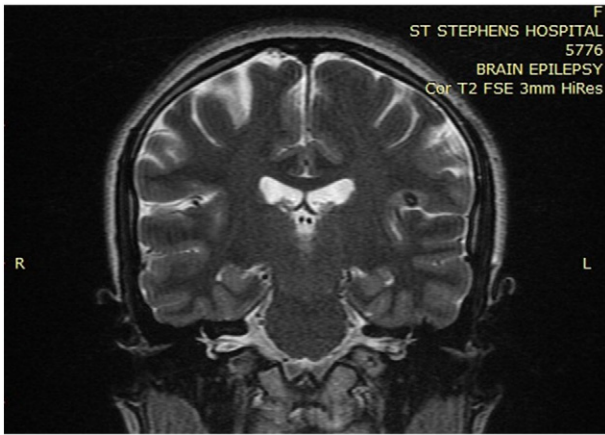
1.5-T MRI coronal T2 showing hypointense round lesion (4.5 mg) with an isointense center located in the posterior parietal operculum.
